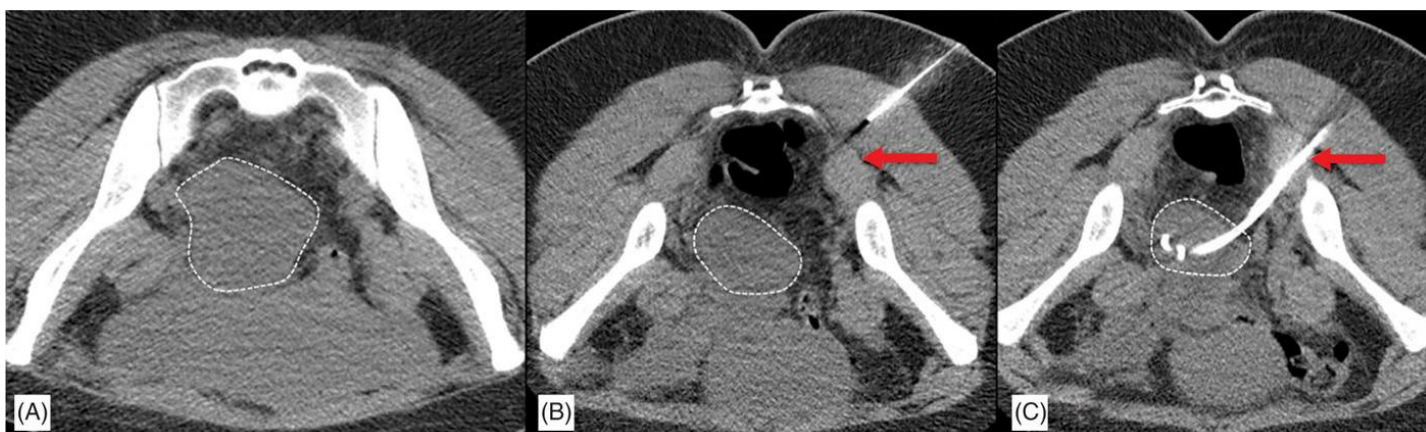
CT-guided pelvic collection drainage using angled gantry approach. (A) Axial CT clearly identifies pelvic collection (dotted lines) but without clear needle access. (B) Tilting the CT gantry and repeat imaging identify a safe angled direct needle trajectory. (C) Pigtail drain tube successfully placed into pelvic collection.
